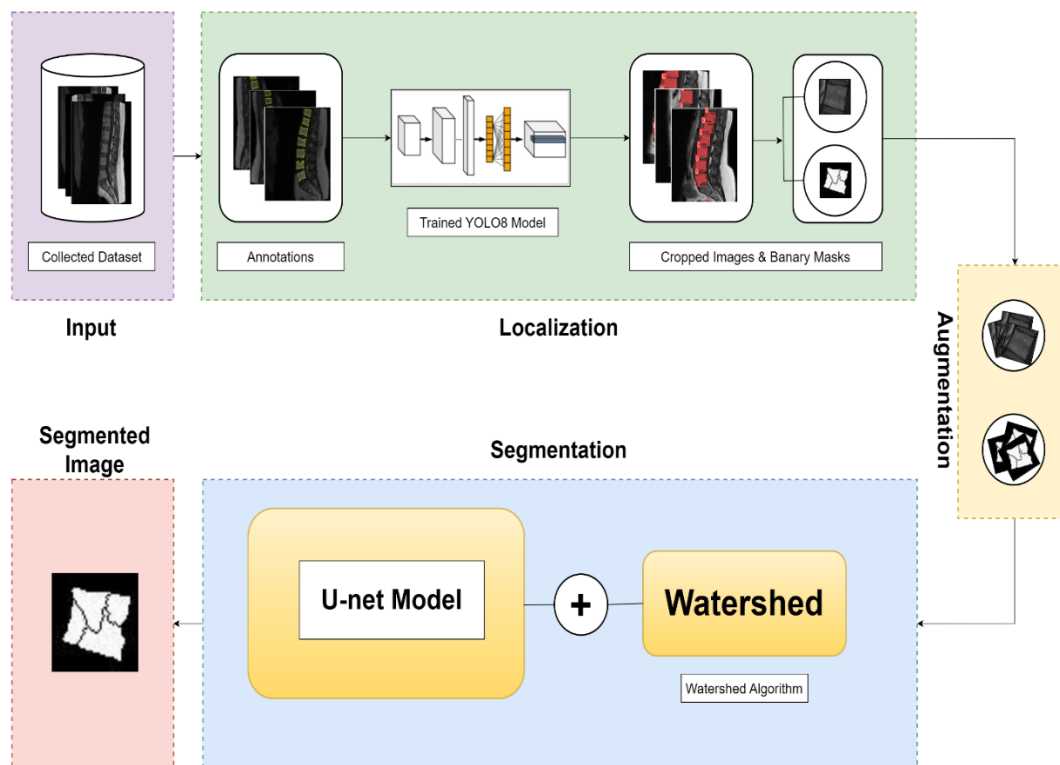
Overview of the methodology: sequential localization and segmentation of spinal structures in MRI images.
